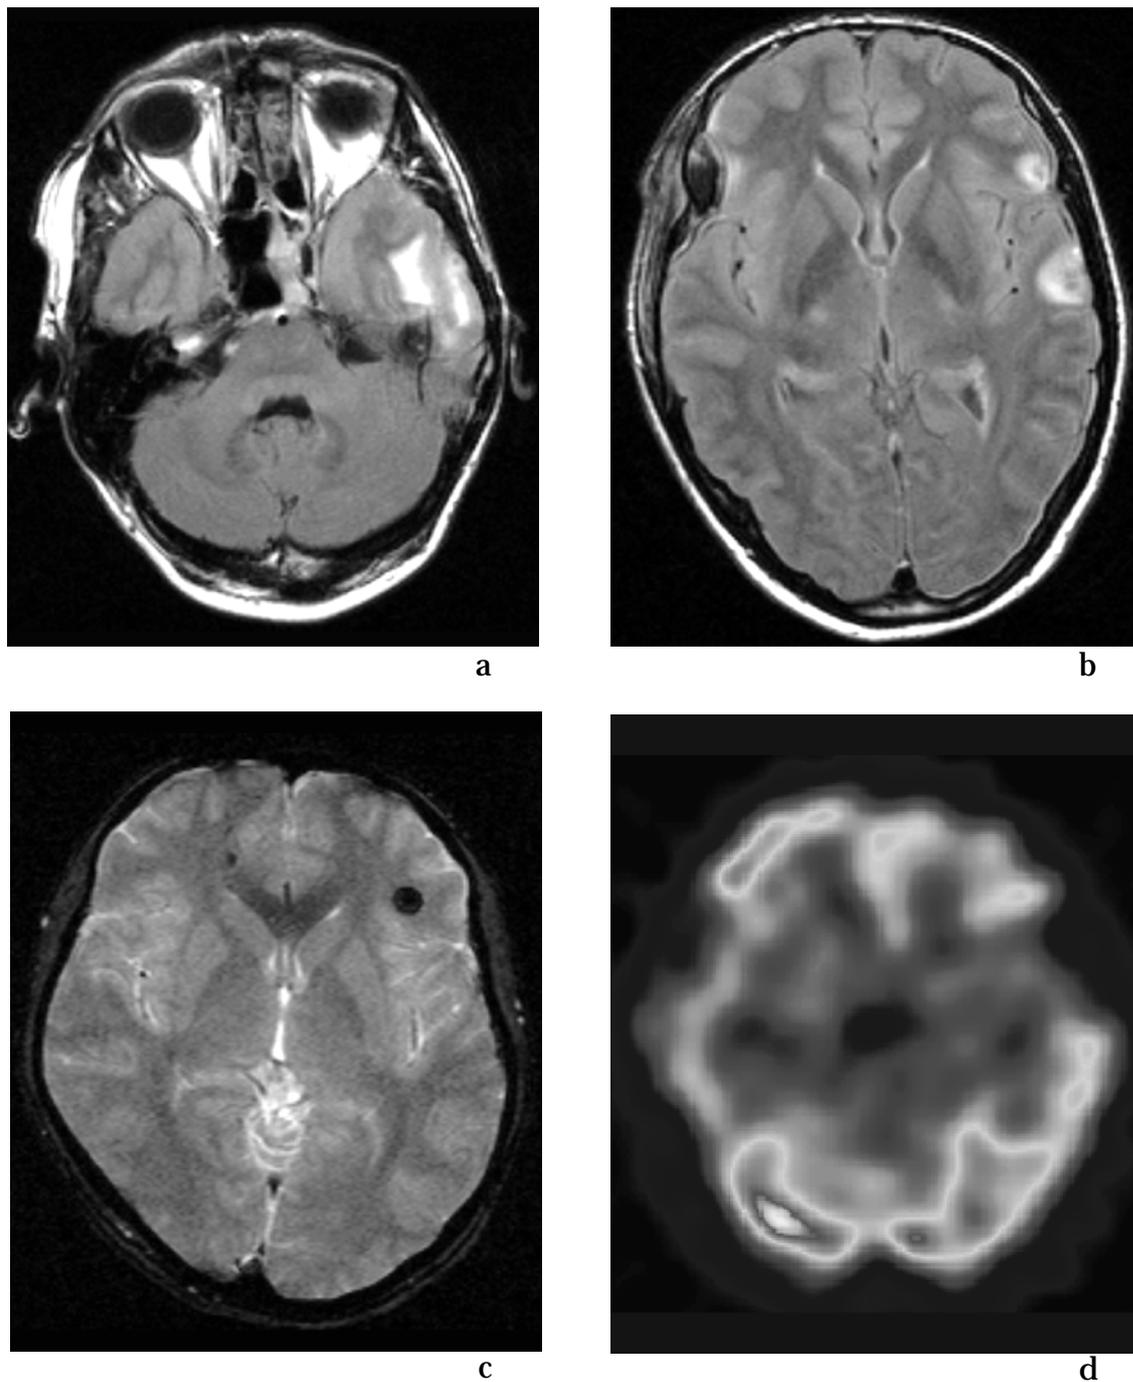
Mild traumatic brain injury. FLAIR images of a 36-years-old male who fell from a bicycle. Contusions are seen in the left temporal lobe as well as in the left frontal lobe. Note also the right frontal extra-cerebral haemorrhage (a & b). Two deep haemorrhagic lesions are seen on the T2- weighted image of a 23-year-old male who had a car accident (c). SPECT image of this patient shows a left frontal perfusion deficit (d), MRI showed no lesions at this location (not shown).*
